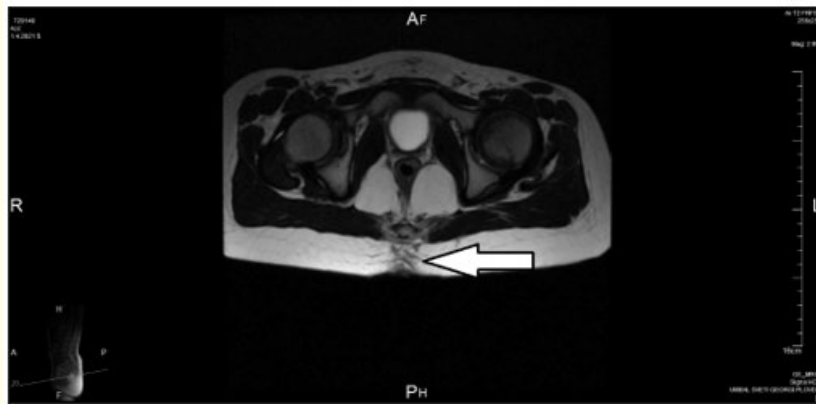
Postoperative MRI. The arrow indicates the lesion site with no signs of recurrence or residual formation.
